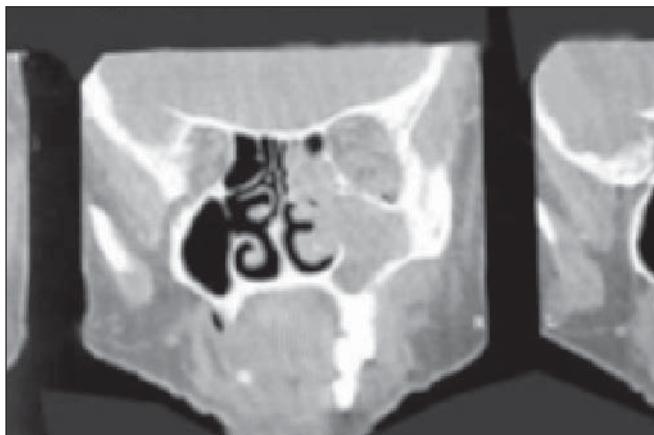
CT Scan of mucormycosis in the maxillary sinus
